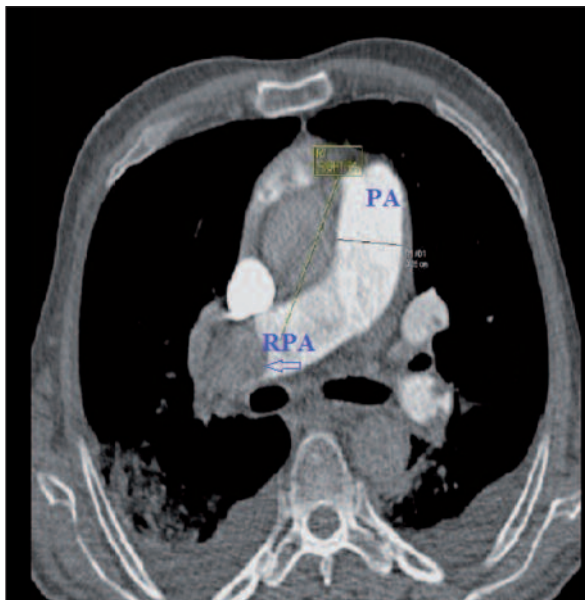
Thrombus in the right pulmonary artery (RPA) is shown with an arrow in the multislice CT image. PA: Pulmonary artery.
